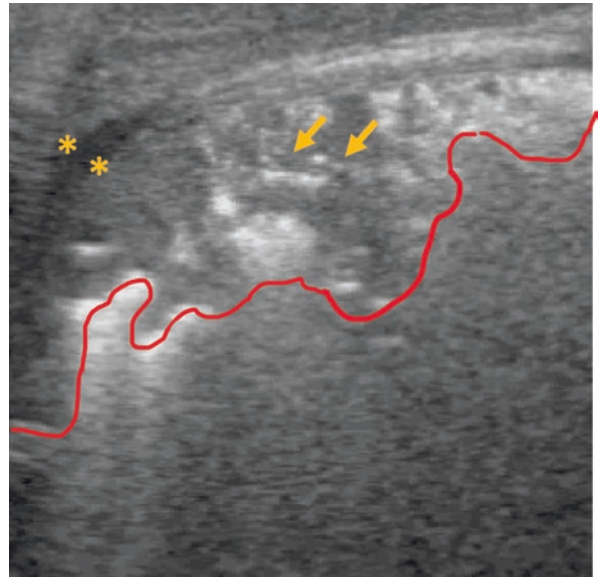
Meconium aspiration syndrome (MAS). Lung ultrasound images from a neonate presenting with severe MAS. Lung ultrasound reveals heterogeneous findings related to injury and obstruction by meconium. Panel a: scan of the anterior chest wall showing an irregular pleural line with small consolidations (arrows) and multiple
